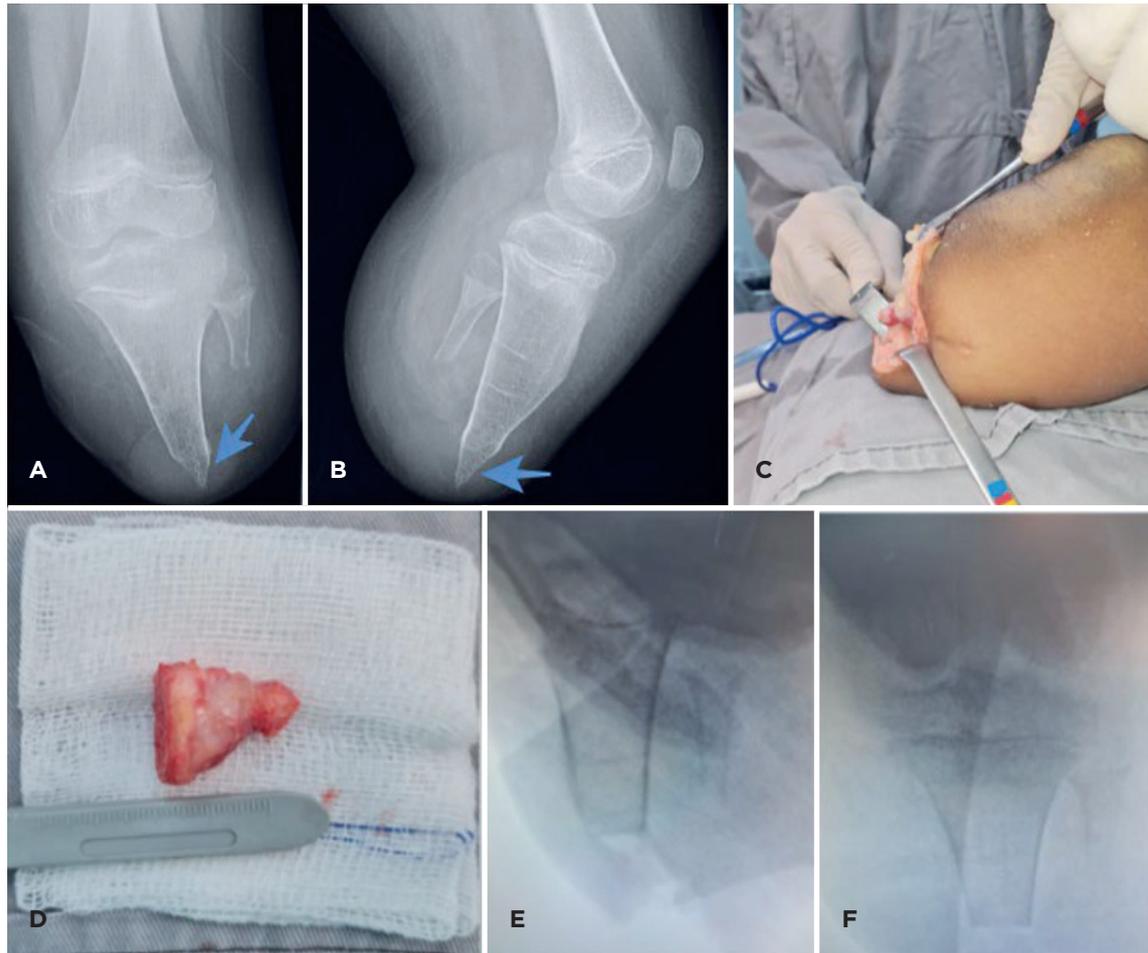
(A and B) Anteroposterior and lateral radiograph images showing a distal spur formation on the tibia (blue arrow) (C and D) Surgical procedure involving exposure and resection of the spur, respectively (E and F) Intraoperative fluoroscopy images demonstrating the resection of the bone spur.
